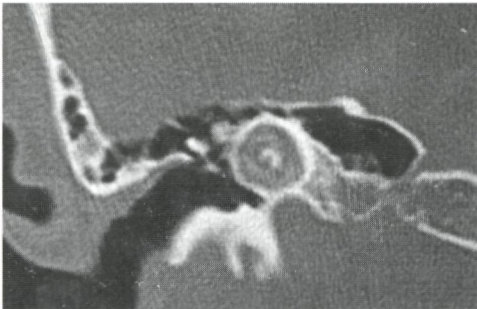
Preoperative CT scan right petrosal bone (coronal view): unrecognizable otic capsule (Type 3).
